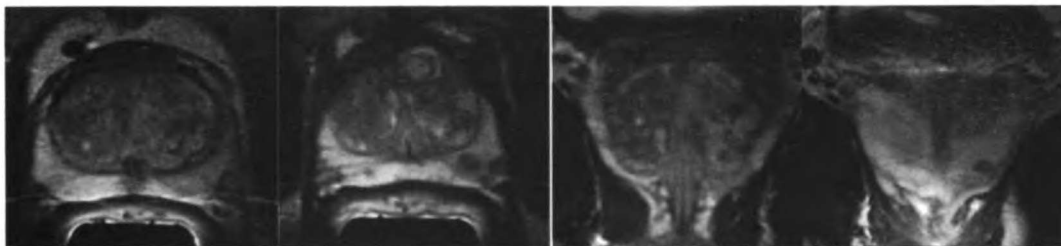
Oblique axial (left) and oblique coronal (right) T2-weighted fast spin-echo images of the human prostate acquired using the coplanar $^1\text{H}/^{31}\text{P}$ dual-tuned endorectal coil.
